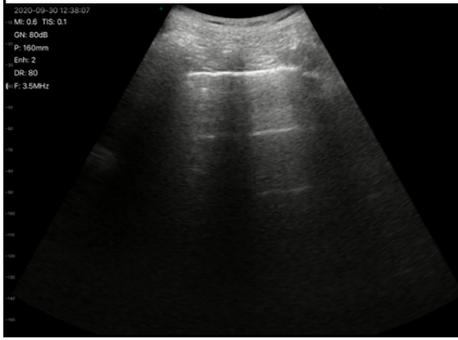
Lung ultrasound Zaragoza score (LUZ-score)
